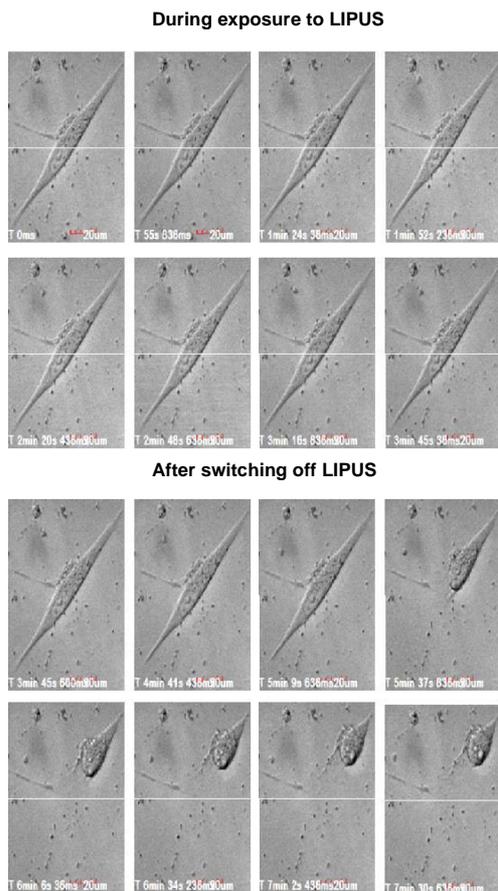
Time series bright field images showing cytomechanical changes of MG63 cells during 1.7-MHz ultrasound pulsing with 30mW/cm² spatial peak time averaged ultrasound intensity and burst rate of 1 kHz at an interval of 200µs for 3min 45 sec time duration. Time-lapse cell shrinkage is evident during post exposure ultrasound period while cell expansion during ultrasound exposure was relatively less prominent.
